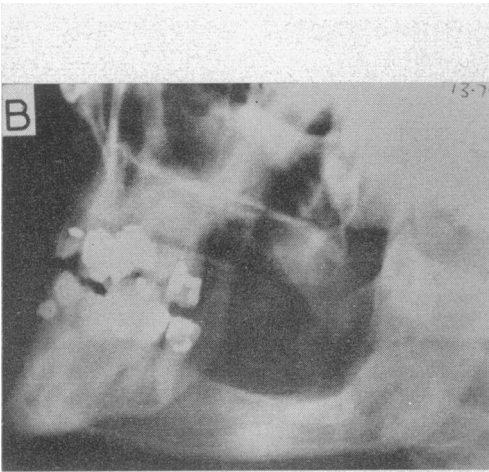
A, large cyst of ramus recurring after enucleation nine years previously; treated with a cyst plug; regression appeared to proceed satisfactorily. B and C, six years later radiographs in two planes appear normal. D and E, sixteen years after the second treatment a recurrence develops in the area previously free from evidence of cyst
